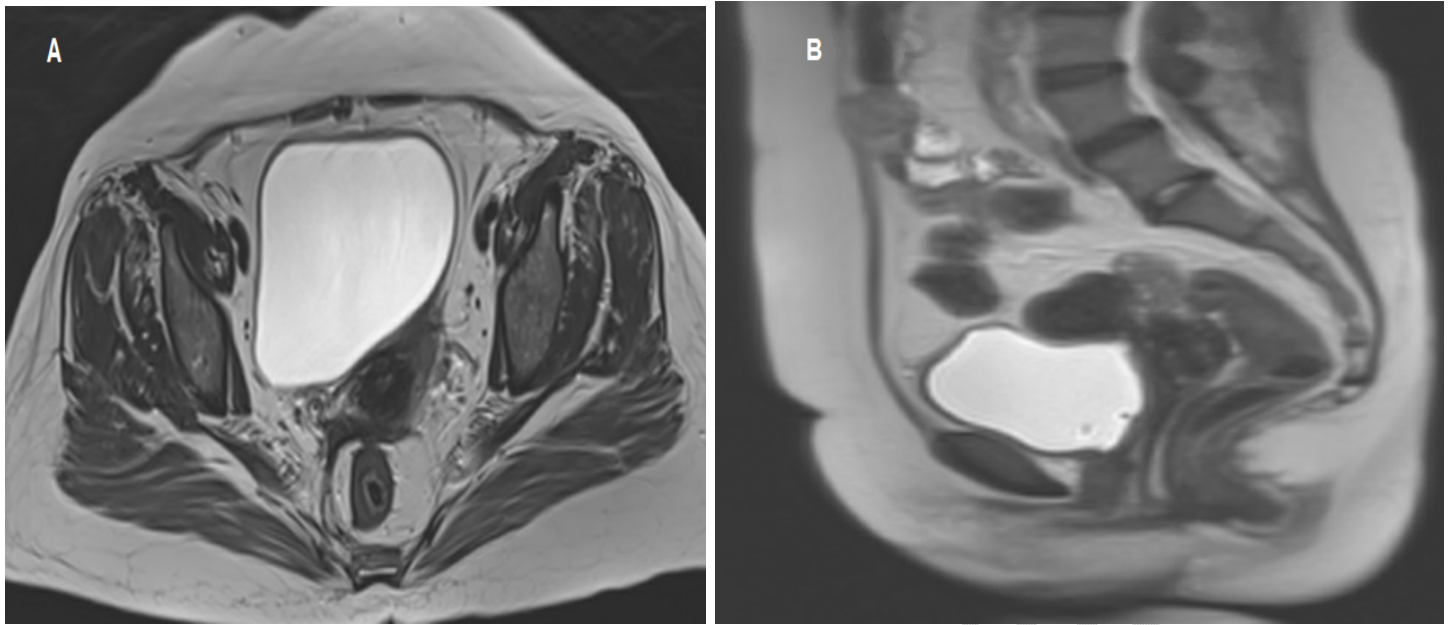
(A-B): The MRI of the pelvis showed thickening with enhancement of the rectum.
